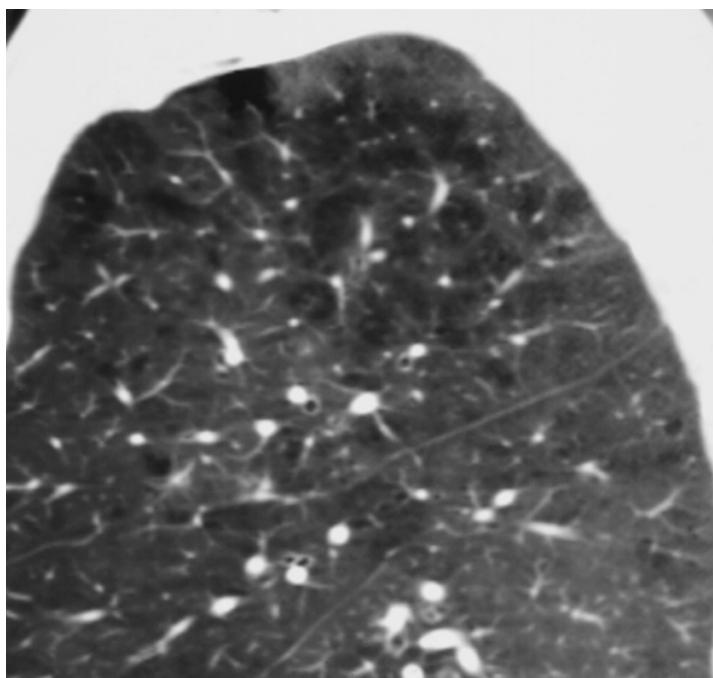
CT image of centrilobular emphysema. The sagittal reconstruction shows emphysema beginning in the center of the secondary lobule with findings most pronounced in the apical lung. In some areas of advanced disease, entire lobules are involved.
